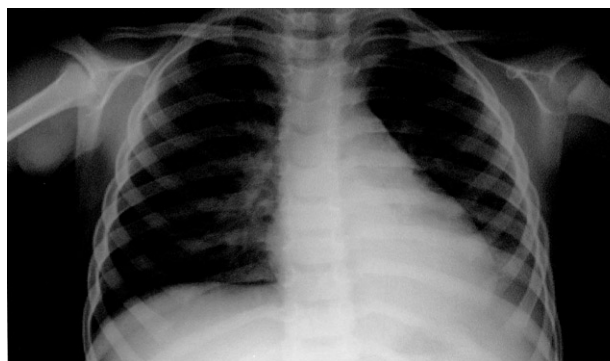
Radiologic finding on admission. Chest radiograph shows consolidation in left lower lung field and blunting of the costophrenic angle.
